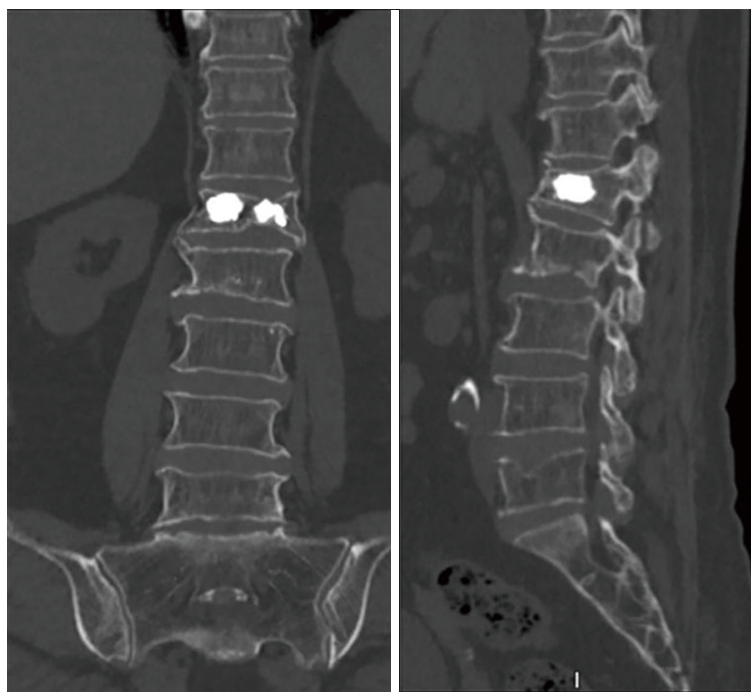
Preoperative CT showing high signal intensity in L1 caused by cement filling, and wedge-shaped changes of L2 vertebral body.
